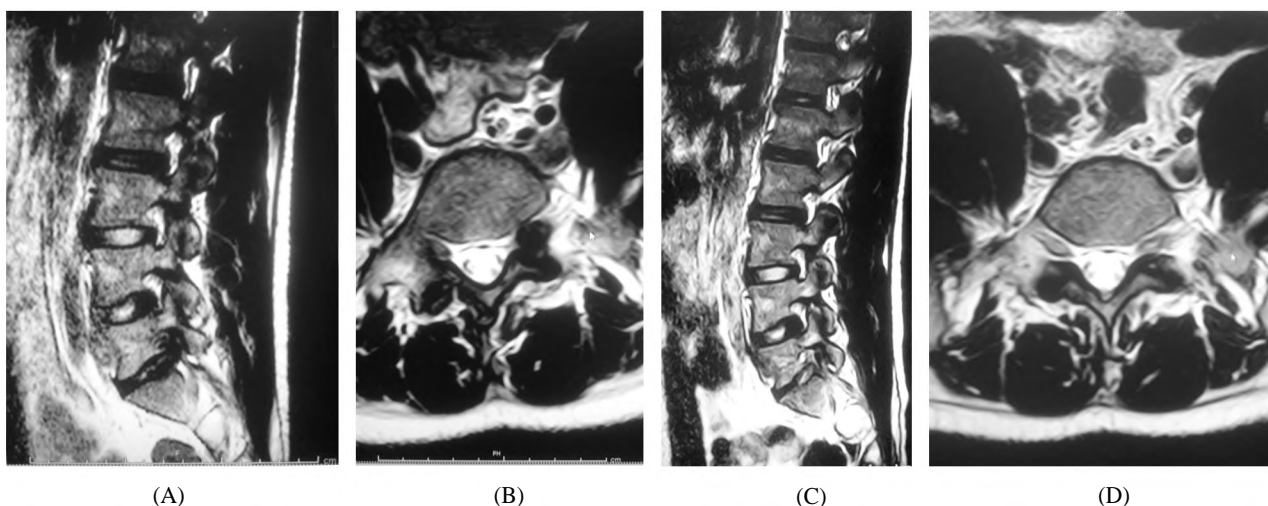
(A,B) Pre-operative and (C,D) Post-operative MRI of a 19 year old military cadet with L5-S1 foraminal disc herniation.
